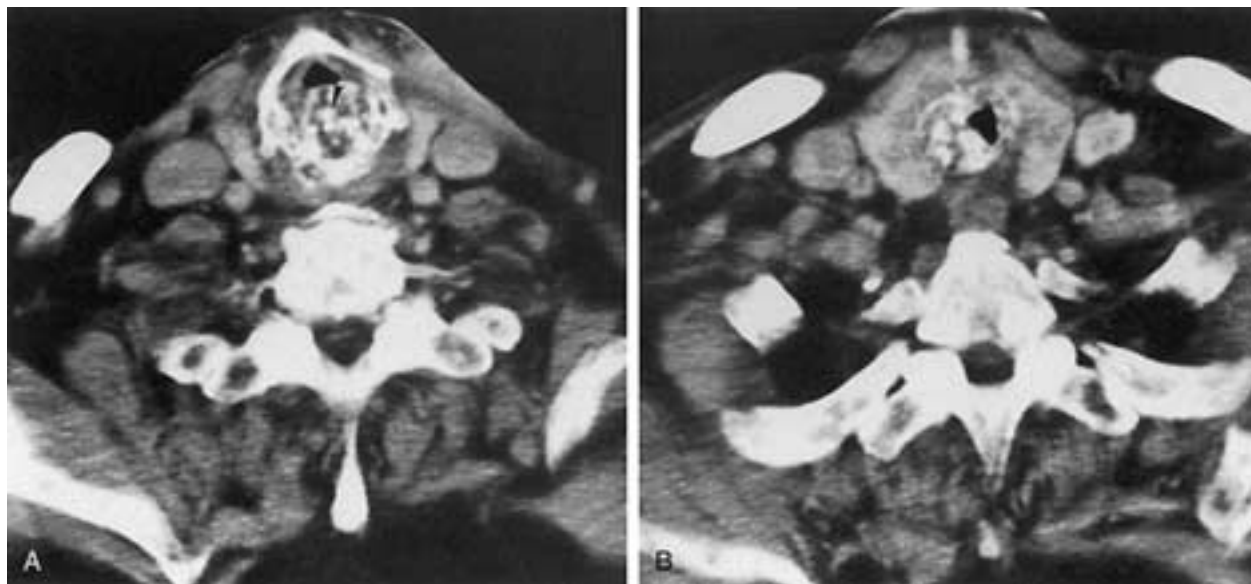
Chondrosarcoma of the larynx. A, CT shows definite ring-like calcifications (*arrowhead*) within the tumor mass. B, Inferior extension shows similar calcifications.
